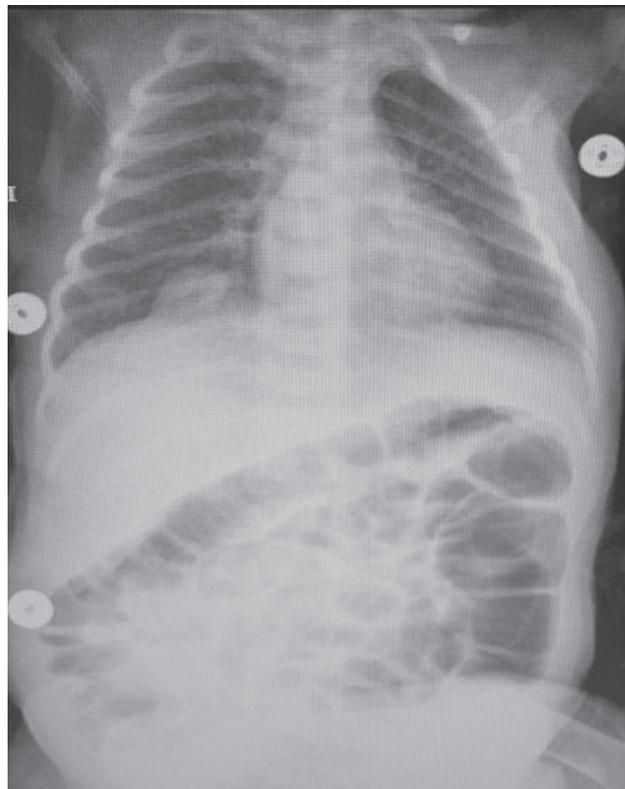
A-P chest X-rays.
